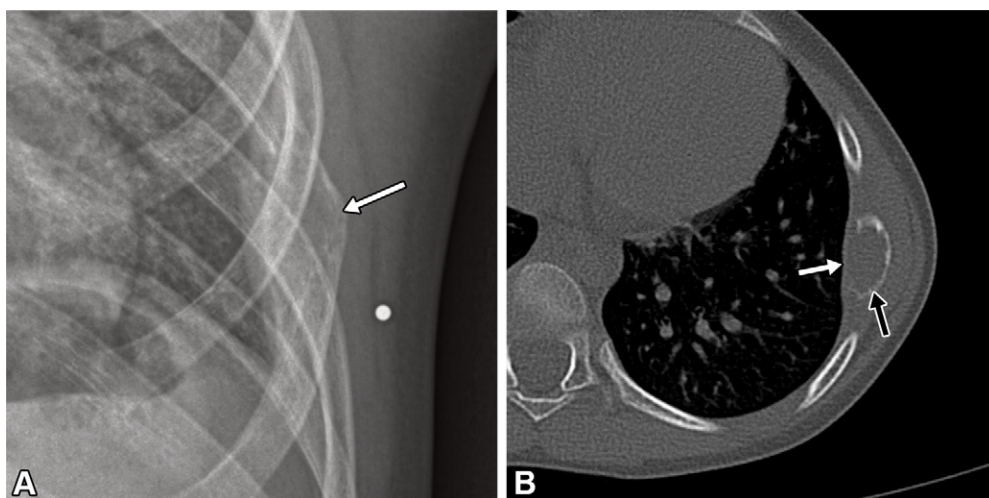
LCH of a rib in a 5-year-old boy who presented with chest pain. (A) Frontal chest radiograph shows a slightly aggressive expansile osseous lesion of the lateral segment of the left seventh rib (white arrow). (B) Axial CT image of the chest shows a focal expansile osteolytic lesion (black arrow) with a moth-eaten type of cortical destruction (white arrow) without an extraosseous soft-tissue mass or internal matrix.
